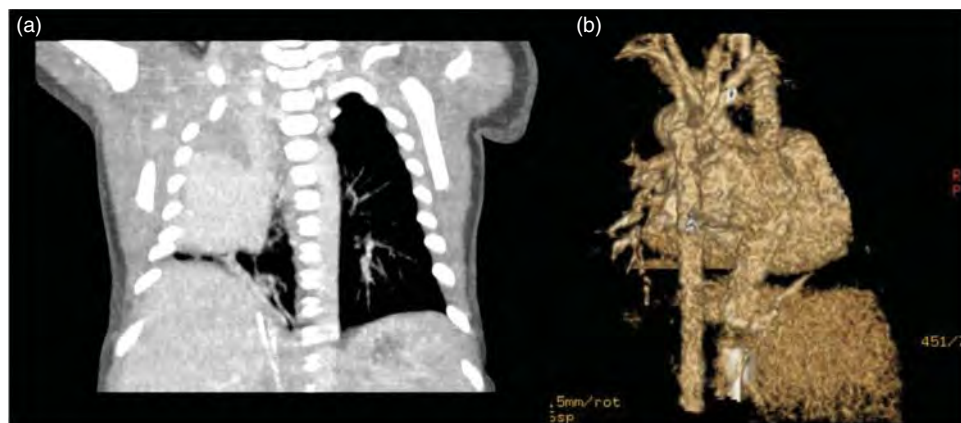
Scimitar syndrome. CT images: (a) hypoplastic right lung and dextroposition of the heart; (b) a volume-rendered angiogram. A small right pulmonary vein connects to the IVC–right atrial junction.
